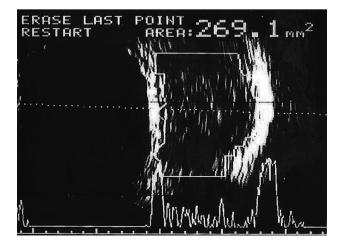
Ultrasonography of Case 2 showed low to moderate echogenicity.
